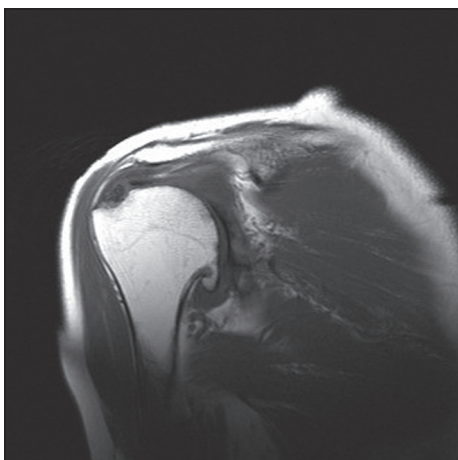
T2 weighted coronal MRI scan showing partial tearing of the supraspinatus tendon attachment. No full thickness tear or retraction is identified
